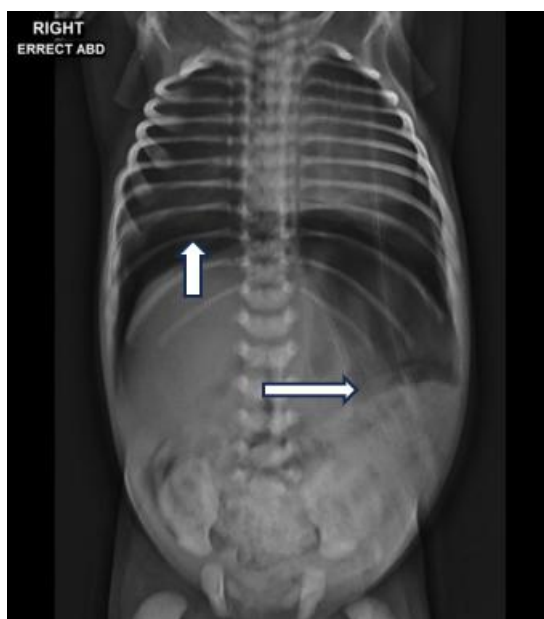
Erect Abdominal Radiograph showing signs of pneumoperitoneum: dilated bowel loops (left horizontal arrow), subdiaphragmatic free air (Right upper arrow)
